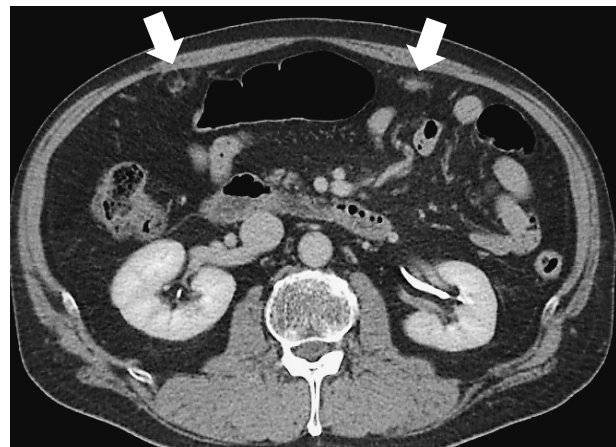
Axial contrast-enhanced CT image taken 4 months after the drainage demonstrating that the abscess had shrunk in size (arrows).
